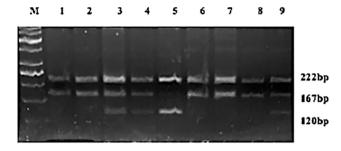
Amplified CLU rs11136000 polymorphism related region was digested with MluCl and run on 3% gel electrophoresis. The gel in the figure shows the different genotypes obtained. M shows the marker. Lane 3, 4, & 9: shows the CT genotype yielded the 222, 167, and 120 bp DNA fragments. Lane 5: shows the TT genotype yielded the 222 and 120 bp DNA fragments. Lane 1, 2, 6, 7, & 8: shows the CC genotype yielded the 222 and 167 bp DNA fragments.
